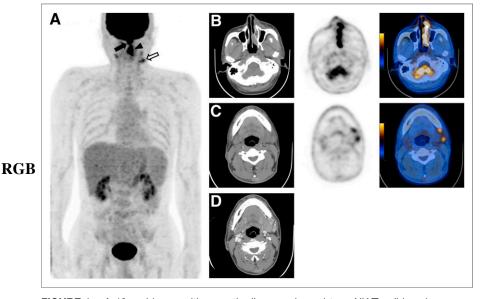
A 46-y-old man with recently diagnosed nasal-type NK/T-cell lymphoma underwent ¹⁸F-FDG PET/CT scan (A-C) and enhanced CT scan (D). Maximum-intensityprojection image (A) shows hypermetabolic lesions in nasal cavity (arrow), left tonsil (arrowhead), and left side of neck (empty arrow). Transaxial images of ¹⁸F-FDG PET/CT scan shows ¹⁸F-FDG-avid mass in left nasal cavity that was pathologically proven NK/T-cell lymphoma (B). ¹⁸F-FDG PET/CT scan shows lymph nodes with increased ¹⁸F-FDG uptake in left submandibular area, suggesting malignancy (C). However, contrast-enhanced CT shows lymph nodes, with less than 1 cm of short-axis diameter, which is not consistent with malignancy (D). Results of fine-needle aspiration cytology were positive for lymphoma involvement. Therefore, stage was changed from I to II.
